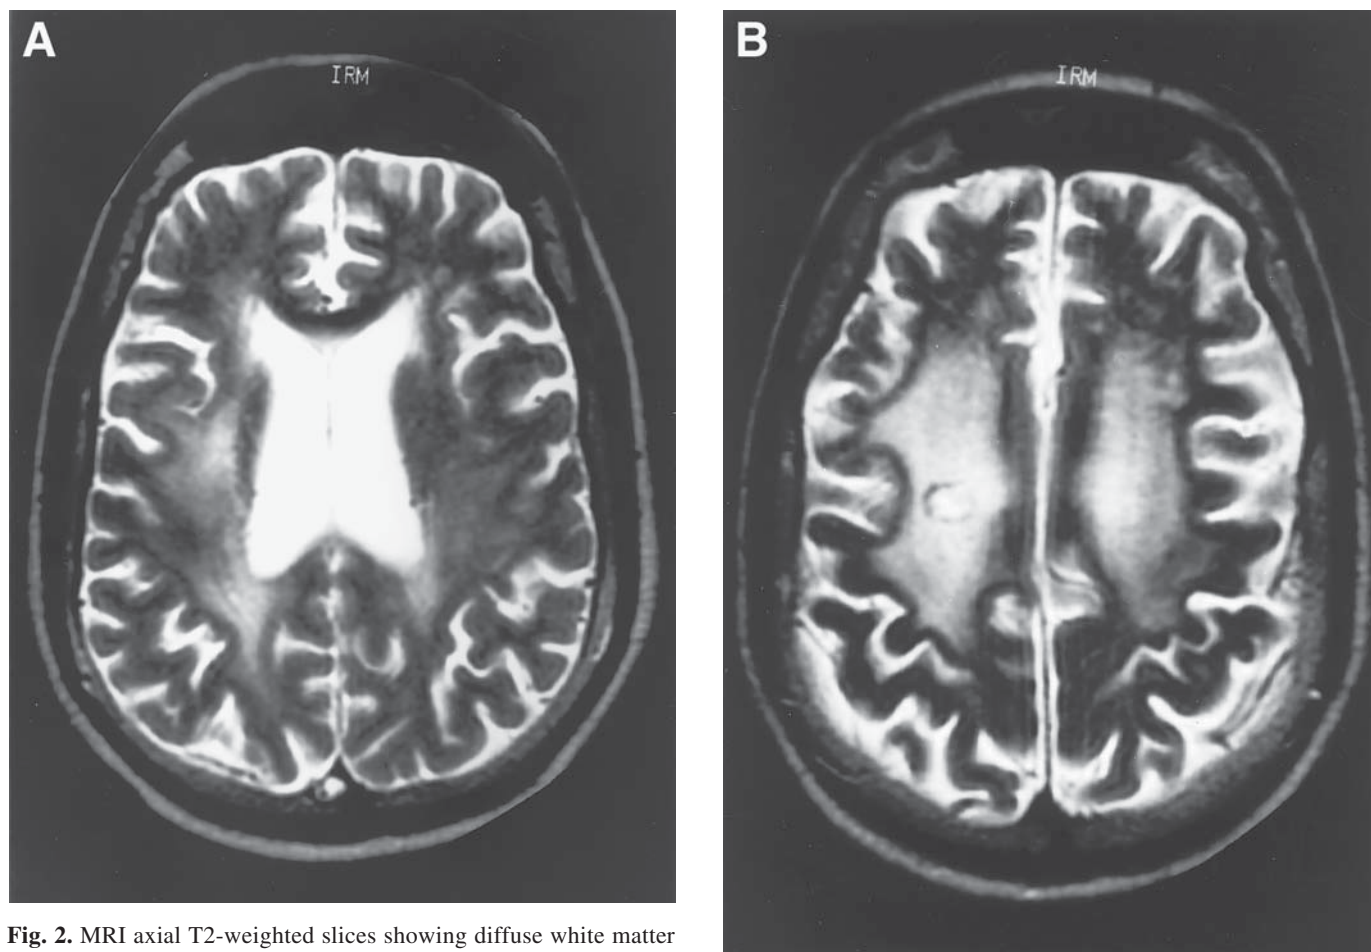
MRI axial T2-weighted slices showing diffuse white matter high signal abnormality in a 50-yr-old patient with severe progressive cognitive impairment 4 yr after external beam conventional RT for a right frontal anaplastic astrocytoma
